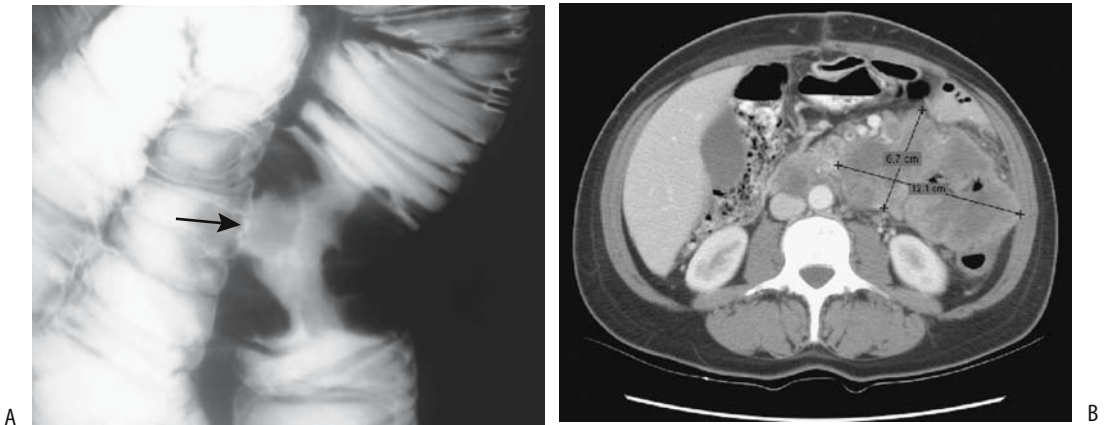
Jejunum adenocarcinoma. A: A typical “napkin-ring” stricture is evident (arrow). B: CT in another patient reveals a heterogeneously enhancing tumor (cursors). Several adjacent jejunal loops are encased by this tumor. (Courtesy of Arunas Gasparaitis, M.D., University of Chicago.)
